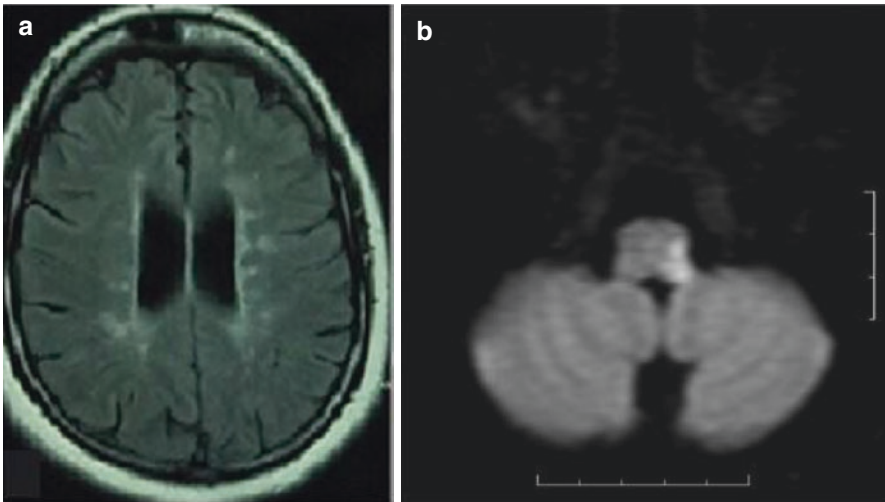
Cerebral magnetic resonance imaging performed at the age of 27 years during hospitalization due to an episode of ictus. (a) Axial flair showing multiple punctate and confluent white matter hyperintensities in the periventricular area. (b) Diffusion restriction in the left lateral medulla oblongata
